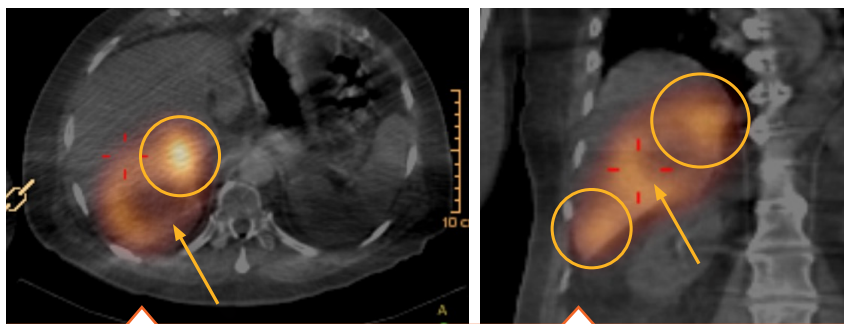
Post-MAA SPECT-CT imaging in axial (left) and coronal (right) projections. Tc-99m MAA was injected via the posterior division of the right hepatic artery through a standard microcatheter. SPECT-CT demonstrates minimal radiotracer activity within the target tumor (yellow arrows) and intense activity in the surrounding hepatic parenchyma (yellow circles).
